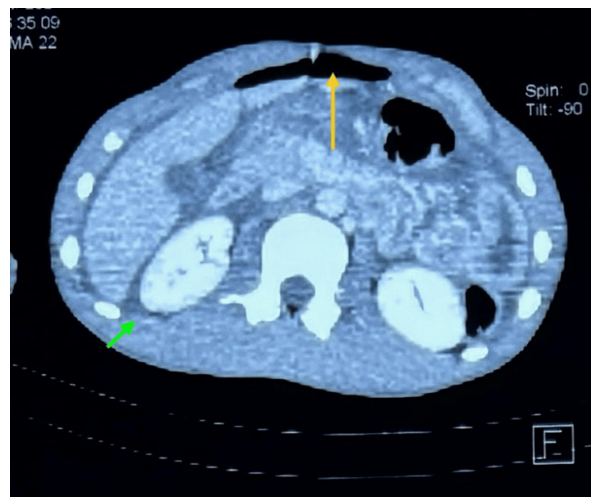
Axial CT scan of abdomen showing pneumoperitoneum (yellow arrow) and intra-peritoneal fluid collection (green arrow).
